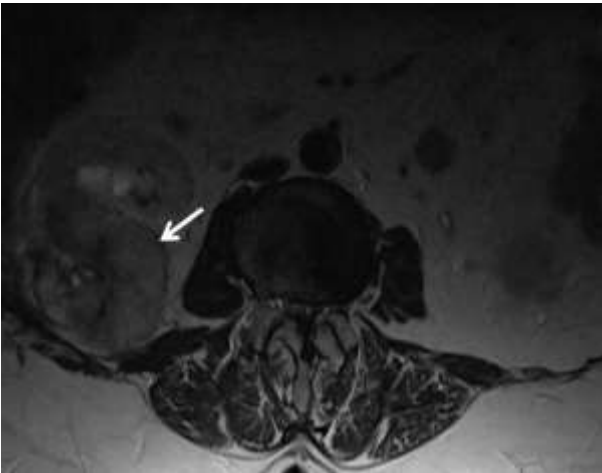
Recurrent mass on axial T2-weighted image in a 66-year-old woman with operated RCC.
